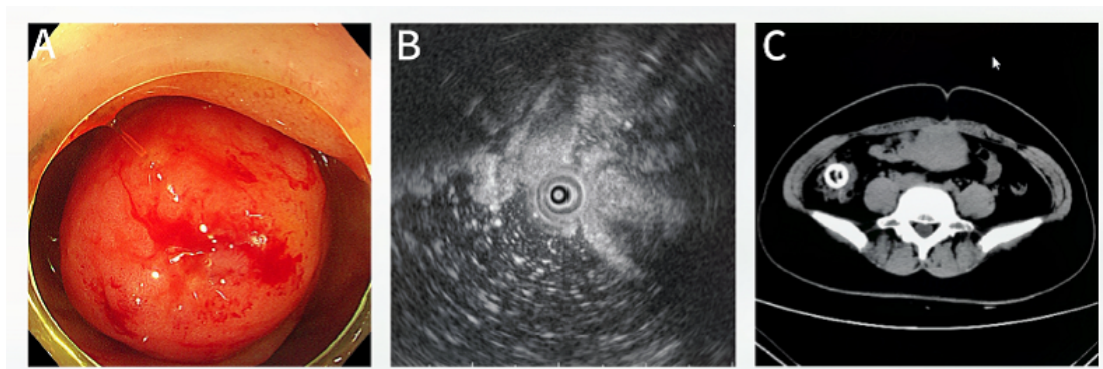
A. Colonoscopy revealed a 3 × 3 cm submucosal tumor-like spherical protrusion in the ileocecal region, with a smooth surface mucosa. B. Endoscopic ultrasonography (EUS) showed mixed echoes in the lesion protrusion, and a 0.21 × 1.83 cm anechoic dark area in the center. C. Contrast-enhanced computed tomography (CT) of the abdomen showed a 2.5 cm non-enhancing ring calcification in the ileocecal region.
